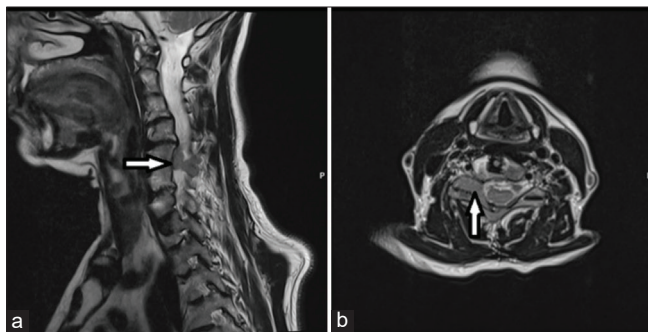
Preoperative sagittal (a) and axial (b) T2-weighted MRI scans revealed the right-sided tumor mass lesion at the levels of C5 and C6. Arrows point to the primary tumor site on both images.
